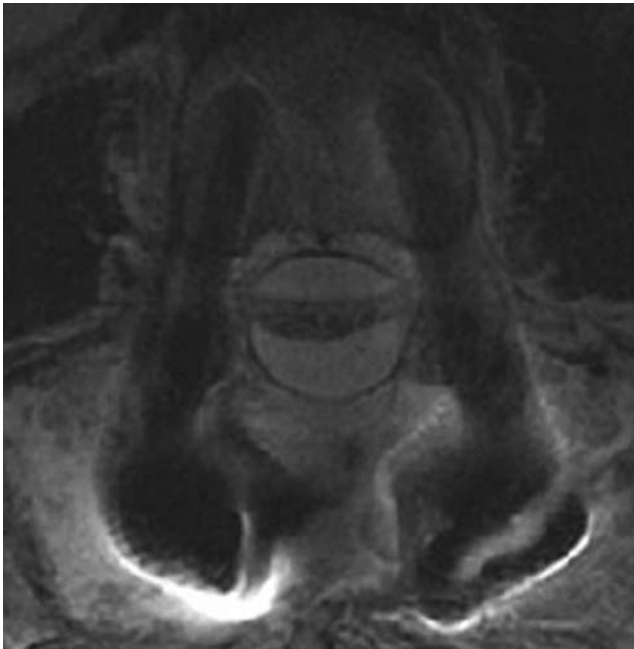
Case 1. Axial MR image showing intradural compression of the cauda equina from an iatrogenic arachnoid cyst.
